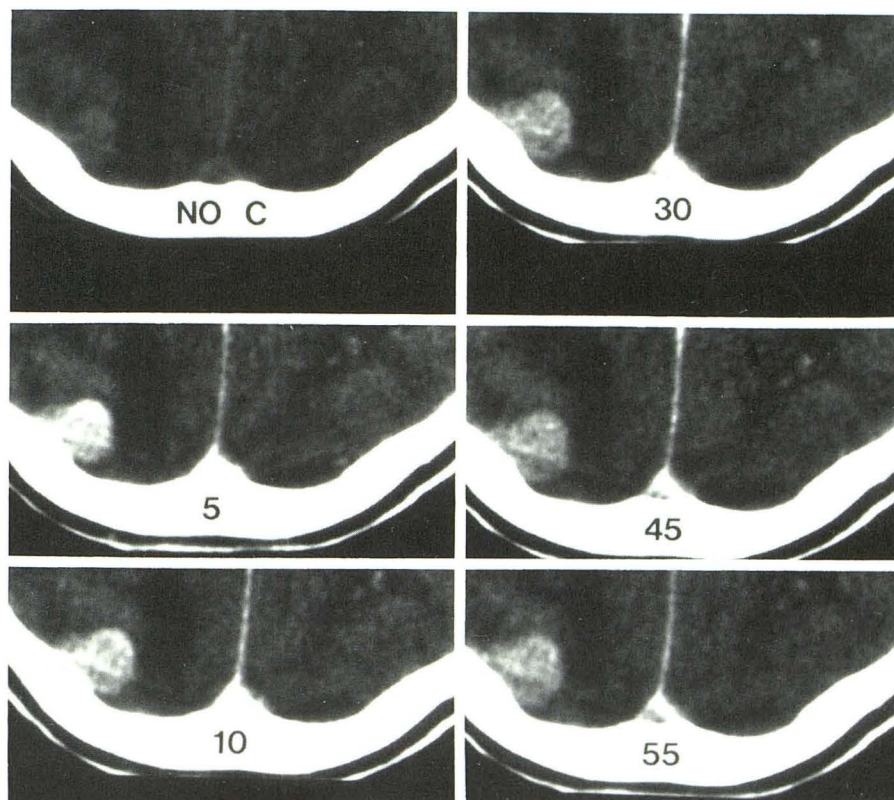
CT images of superior sagittal sinus region prior to contrast infusion (top left), and 5–55 min after injection. Note progressive relative lucency of the sinus relative to dura on delayed images. The patient had an enhancing metastasis in the right occipital lobe, but no clinical indications of sinus thrombosis.
